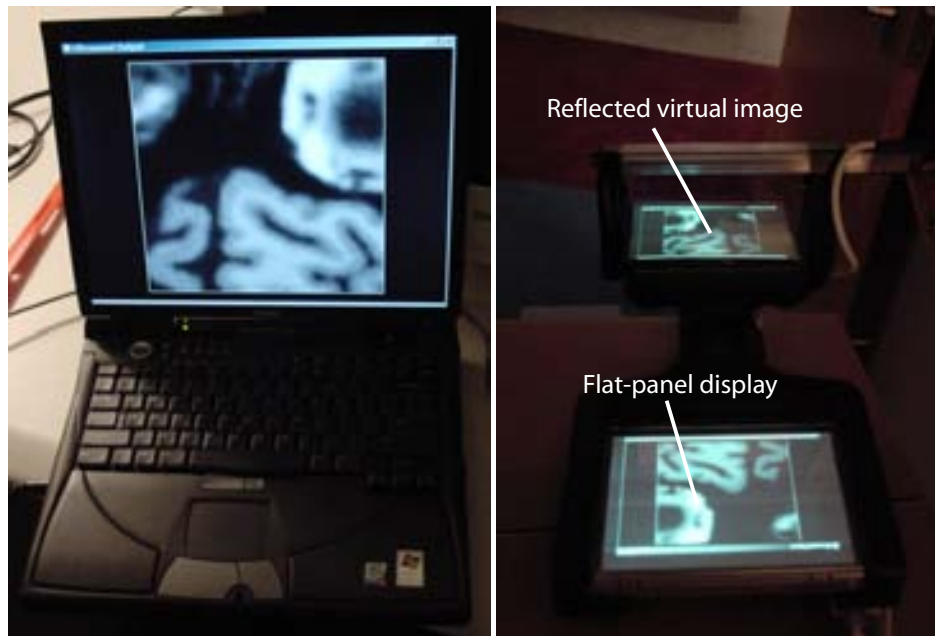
VTR slice through an MRI of the brain, displayed on laptop computer (left) and Sonic Flashlight (right) [16].
